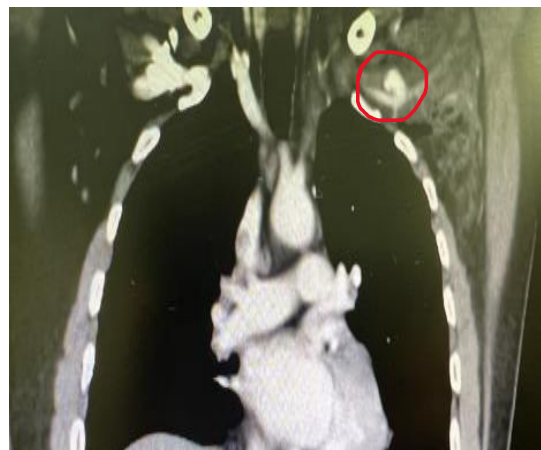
Computed tomography (CT) with intravenous contrast, a well-defined pouch of contained contrast was seen arising from the left subclavian artery
